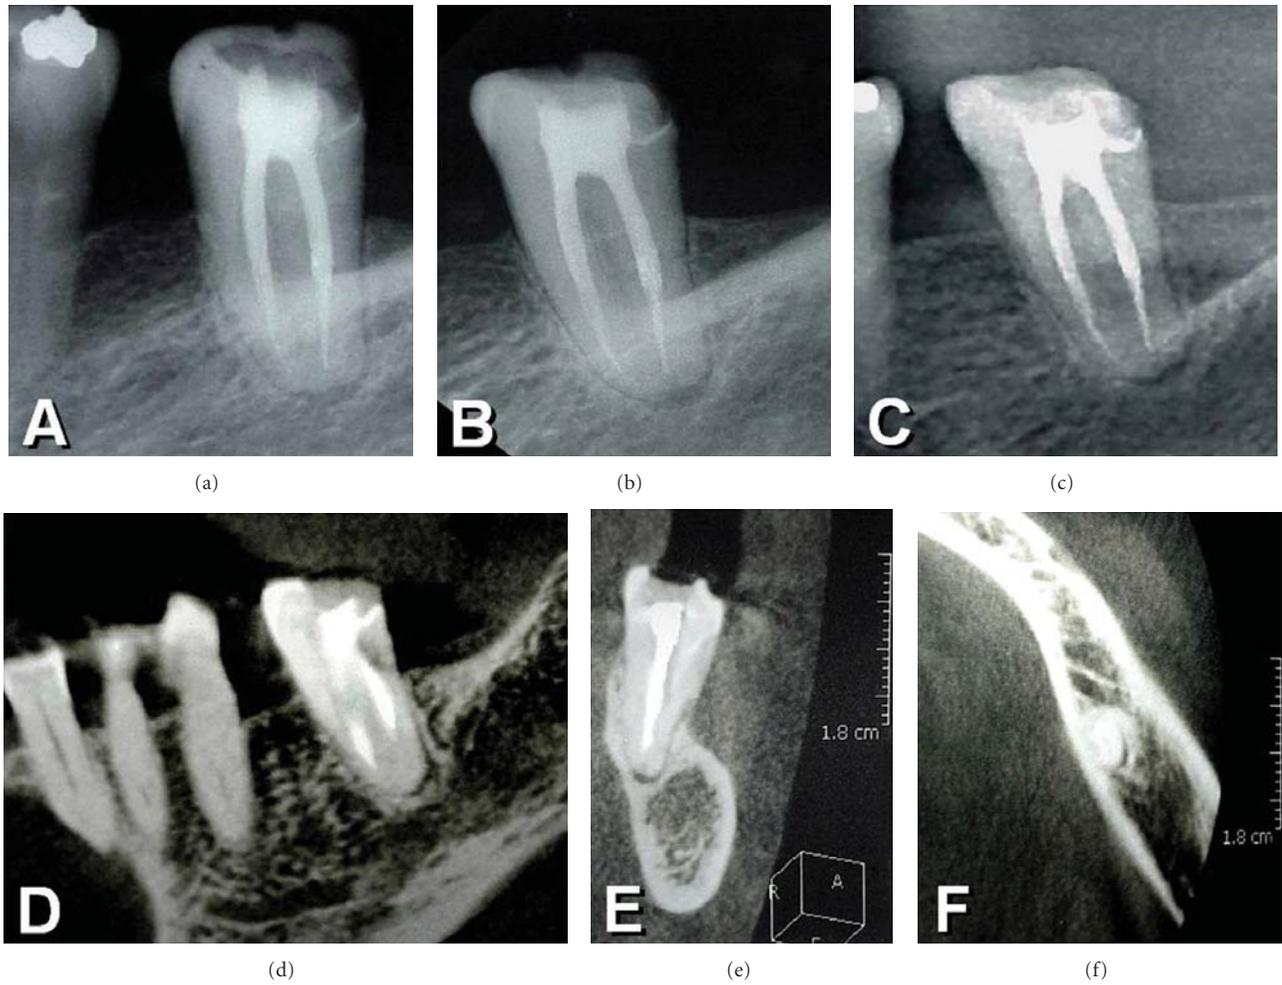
10-year recall radiograph of a left mandibular second molar showing root canals filled with gutta-percha and EndoREZ sealer. (a) Immediate postoperative radiograph of the left mandibular second molar showing root canals filled with gutta-percha and EndoREZ sealer. (b) 8-year recall. (c) 10-year recall. Note the presence of a small residual periapical radiolucent area surrounded by thick cortical bone and normal bone trabeculae. After 10 years the patient was asymptomatic and radiographically the case was evaluated as successful and suggest the presence of an apical scar. (d) Lateral, (e) distal, and (f) occlusal CBCT images confirming the radiographic evaluation.
